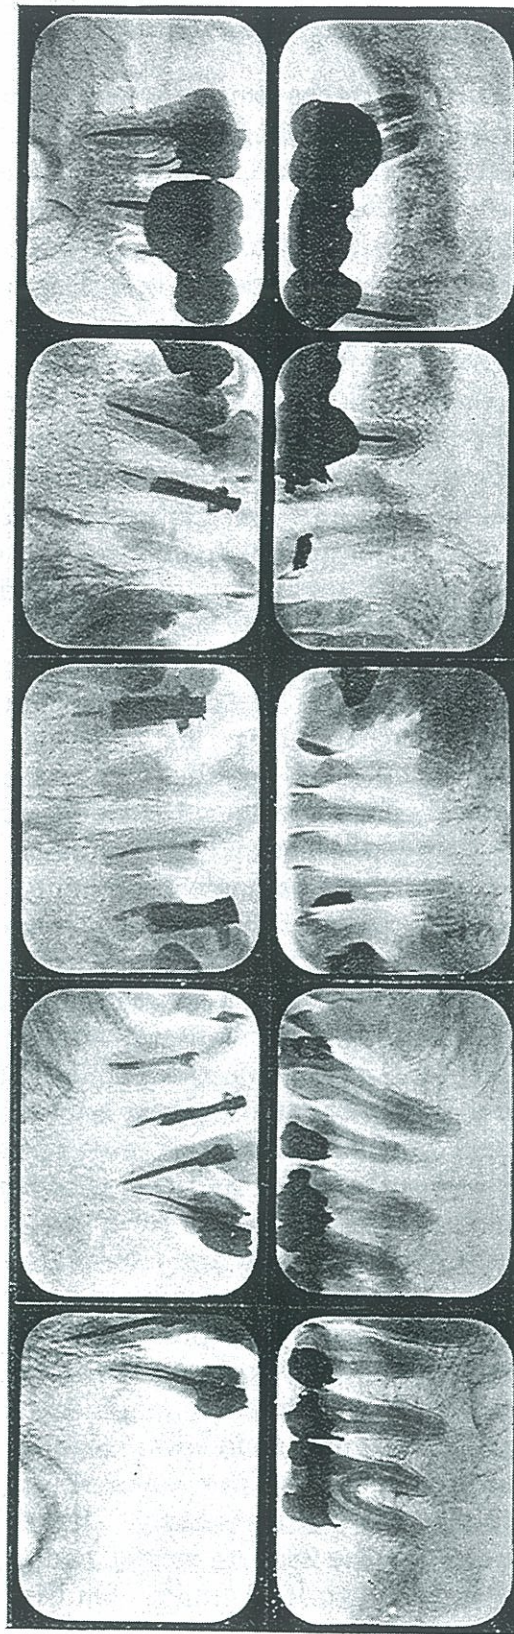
ROENTGENOGRAPHIC APPEARANCE OF THE TEETH. PATIENT SUFFERING SENSITIZATION REACTION FROM HIS DENTAL INFECTION, SHOWN IN FIGURE 166.
